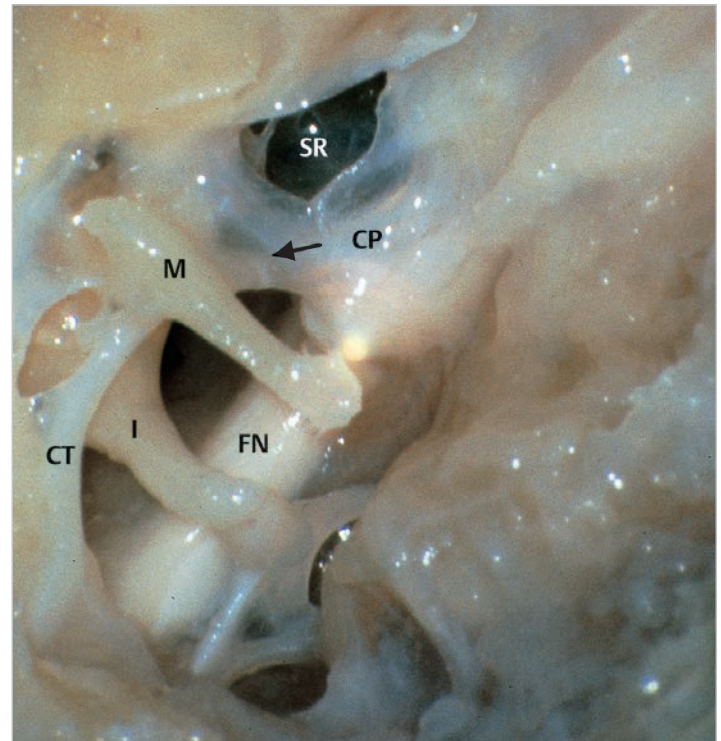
Structures in the medial wall of the mesotympanum as viewed from anteroinferior direction. The tendon of the tensor tympani is seen (arrow). Note the protrusion of the facial nerve and its proximity to the round window. CP, cochleariform process; CT, chorda tympani; FN, facial nerve; I, long process of the incus; M, manubrium of the malleus; SR, supratubal recess.
